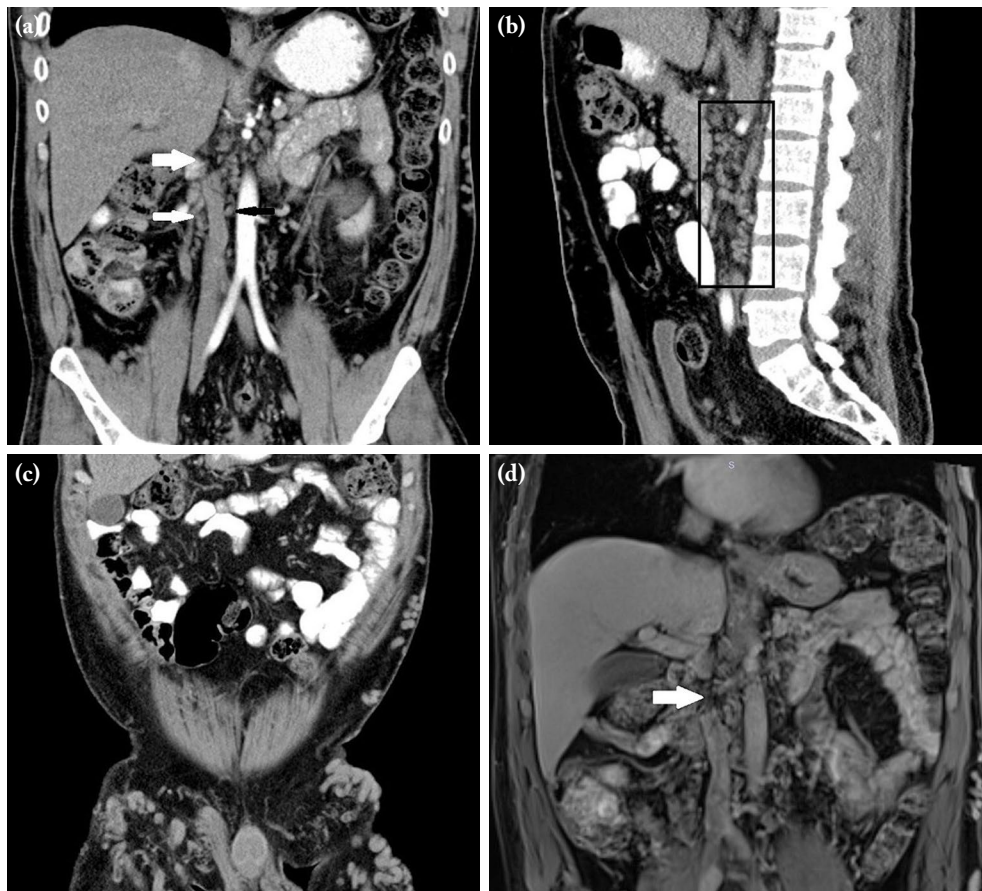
(a) In the coronal cross-sectional contrast-enhanced abdominal CT, the segment of inferior vena cava adjacent to lower contour of liver was not observed (thick arrow). On both sides of this segment, there were dilated and tortuous venous structures compatible with collateral vessels (thin arrows). (b) In the sagittal cross-sectional contrast-enhanced abdominal CT, prevertebral and retroperitoneal collateral dilated venous structures were observed. (c) In the coronal cross-sectional contrast-enhanced abdominal CT, numerous dilated and tortoise veins were observed under skin in both inguinal regions and anterior wall of abdomen on the left. (d) In the post-contrast late phase T1-weighted MR images, the segment of inferior vena cava adjacent to lower contour of liver was not observed.
